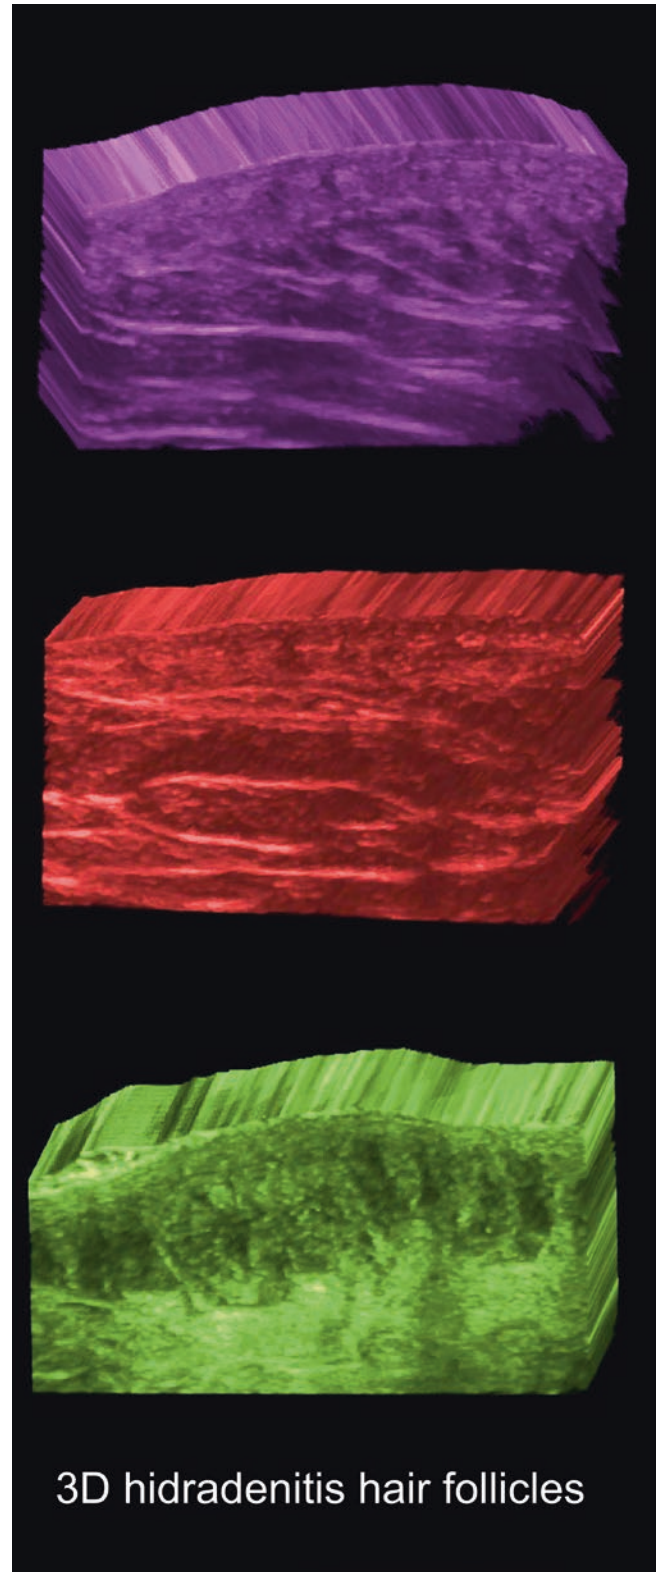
Hidradenitis suppurativa (HS). Widening of the hair follicles. Ultrasound (greyscale; axillary regions) comparative views of normal versus HS hair follicles.
